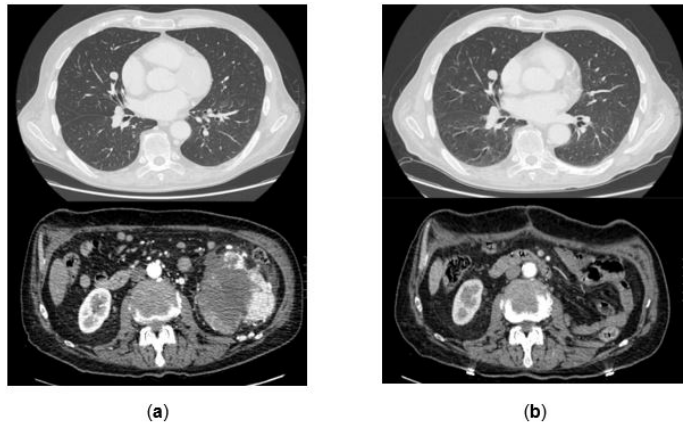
Case 2 Axial CT scan of lung metastases, mediastinal nodes and primitive renal mass before; (a) and after; (b) ICIs/TKI combination treatment and surgery.
